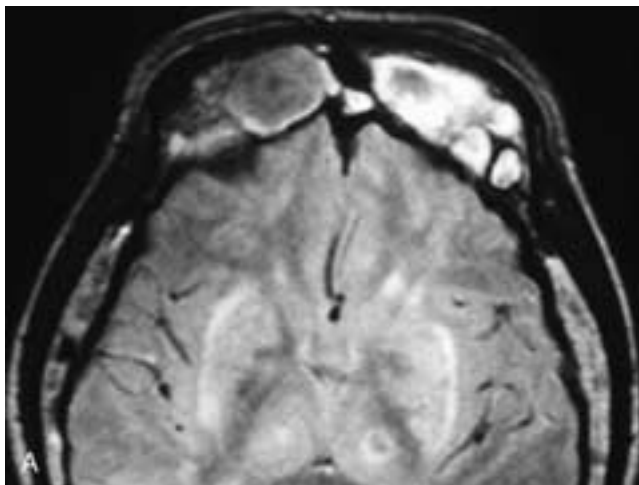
Axial T1-weighted (A) and T2-weighted (B) MR images show bilateral expansile, nonhomogeneous frontal sinus masses. On the right side, the mass has overall low to intermediate T1-weighted and low T2-weighted signal intensities. On the left side, the mass has an overall high signal intensity on both T1-weighted and T2-weighted images. This patient had bilateral frontal sinus mucocoeles.
